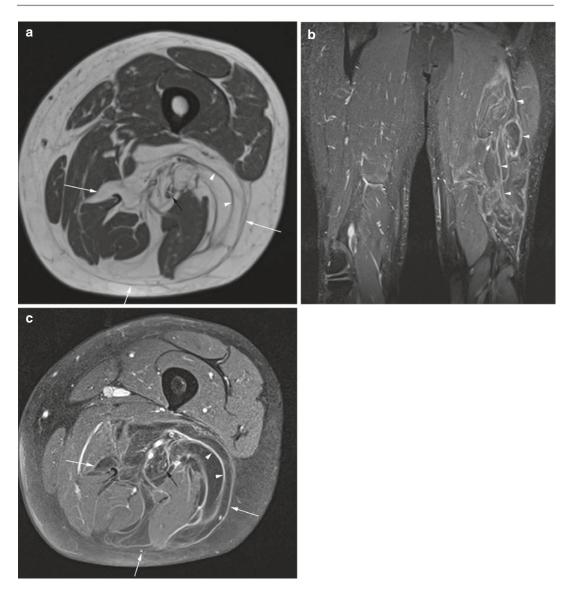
(a, b) Well-differentiated liposarcoma of the left thigh. (a) Axial SE T1-weighted MR image. (b) Coronal fat-suppressed SE T2-weighted MR image. (c) Axial fat-suppressed SE T1-weighted MR image post gadolinium. Images reveal a large infiltrating mass (*white arrows*) enveloping the sciatic nerve (*black arrow*) within
